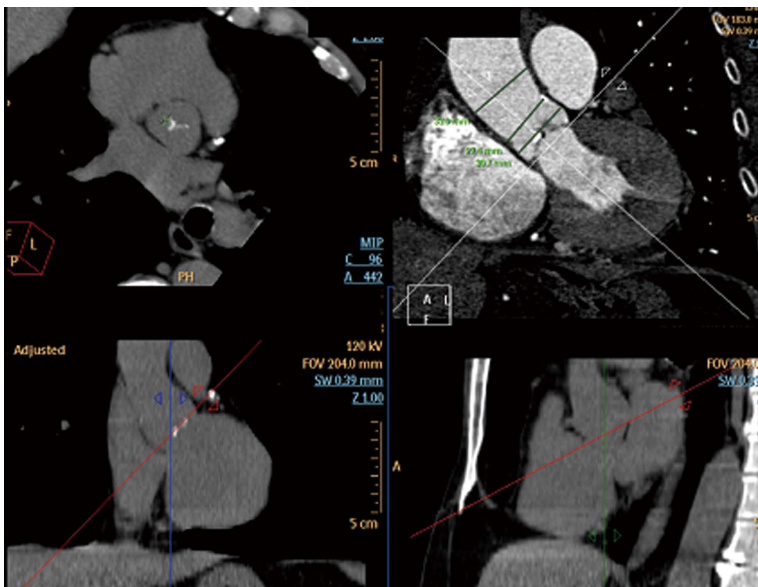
Computed tomography with multiplanar reconstruction showing measurements at different levels of the aorta.
